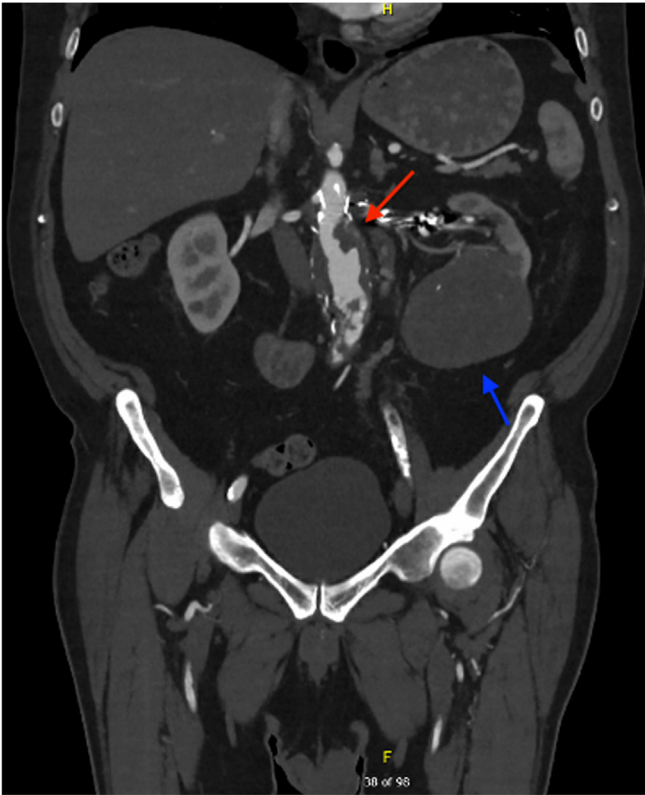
Coronal computed tomography images demonstrating aortic tumor thrombus within the aortic graft (red arrow) and the left renal cell carcinoma (RCC) (blue arrow).
